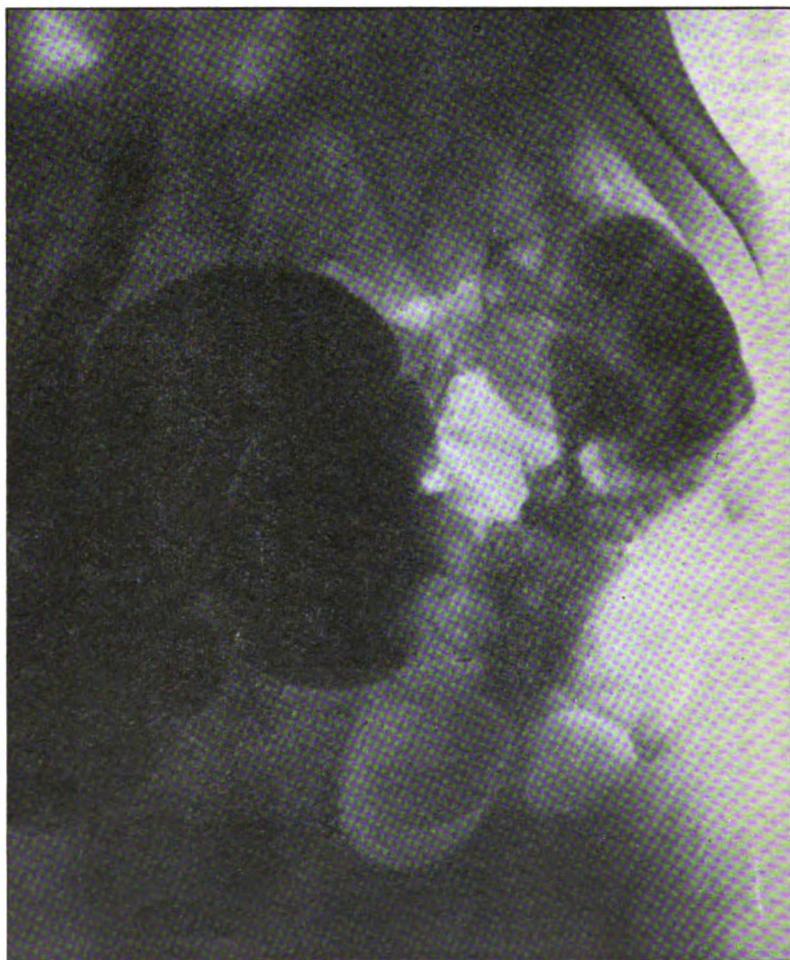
The X-ray appearances of the complex and the abscess cavity taken after evacuation.
